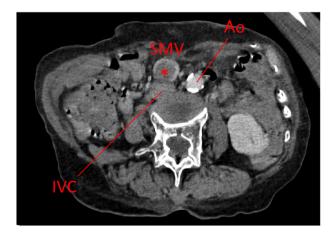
Contrast-enhanced axial computed tomography image, showing giant SMV thrombus. The asterisk indicates the thrombus. "SMV," "IVC," and "Ao" represent superior mesenteric vein, inferior vena cava, and aorta, respectively.
